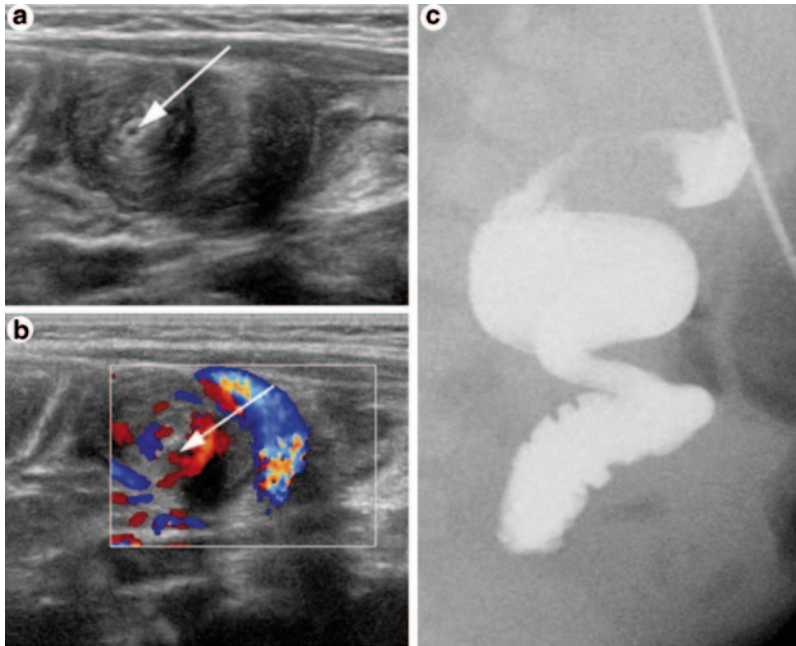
Midgut volvulus diagnosed using ultrasound (US) in an 83-day-old boy evaluated for hypertrophic pyloric stenosis. Gray-scale (a) and Doppler US (b) demonstrate the “whirlpool sign” of the peripheral swirling
